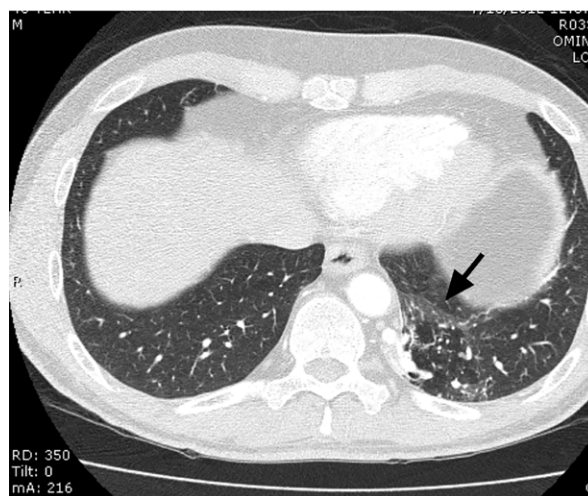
Patient 2. Computed tomogram shows an extralobar pulmonary sequestrum in the left lower lobe (arrow).
